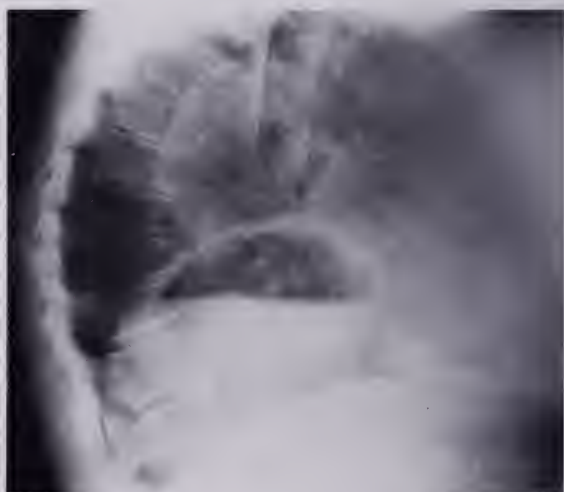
(Case 1).—Lateral view of chest x-ray demonstrates elevated left hemidiaphragm with air fluid level in stomach.
